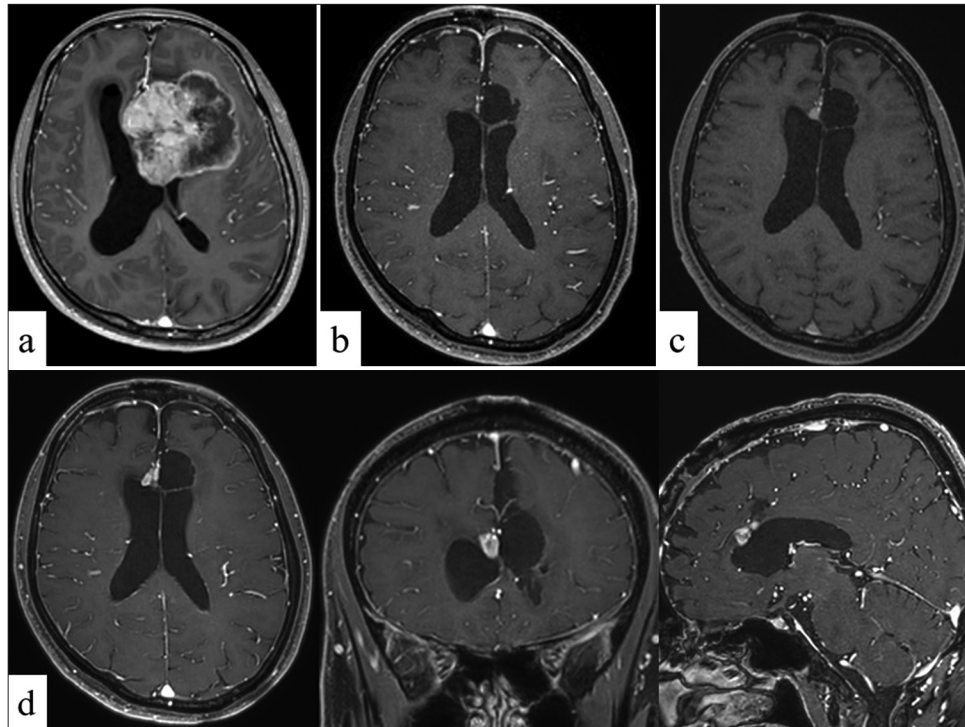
(a) MRI performed before the first operation showing an approximately 60 mm tumor in the interhemispheric fissure of the anterior cerebral region, compressing the left frontal lobe. (b) MRI performed after the first operation showed that the enhanced region had been totally removed. (c) MRI performed 20 months after the first operation showed enlargement of the tumor recurrence in the corpus callosum. (d) MRI performed before the second operation showed a growing tumor infiltrating the corpus callosum and anterior cerebral artery.
